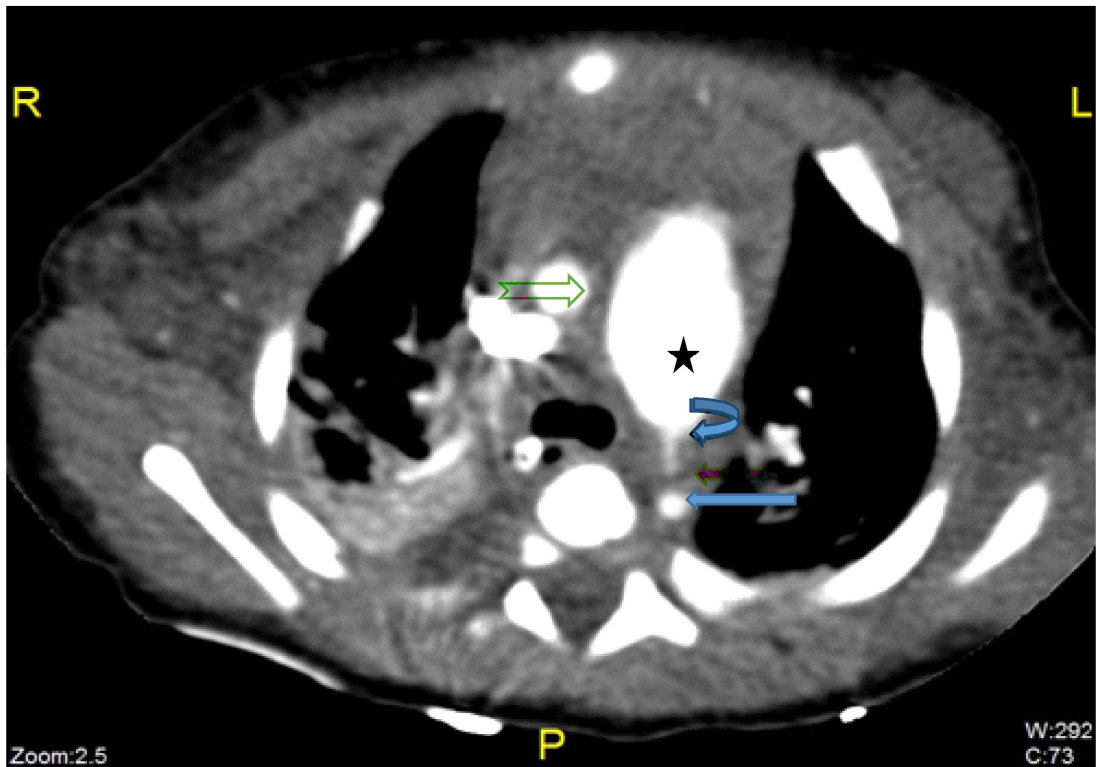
A contrasted CT, axial view at the level of the main pulmonary artery showing the patent ductus arteriosus (curved blue arrow) connecting the main pulmonary artery (star) to the small descending aorta (straight blue arrow). The ascending aorta is also noticed at this level (notched arrow).
